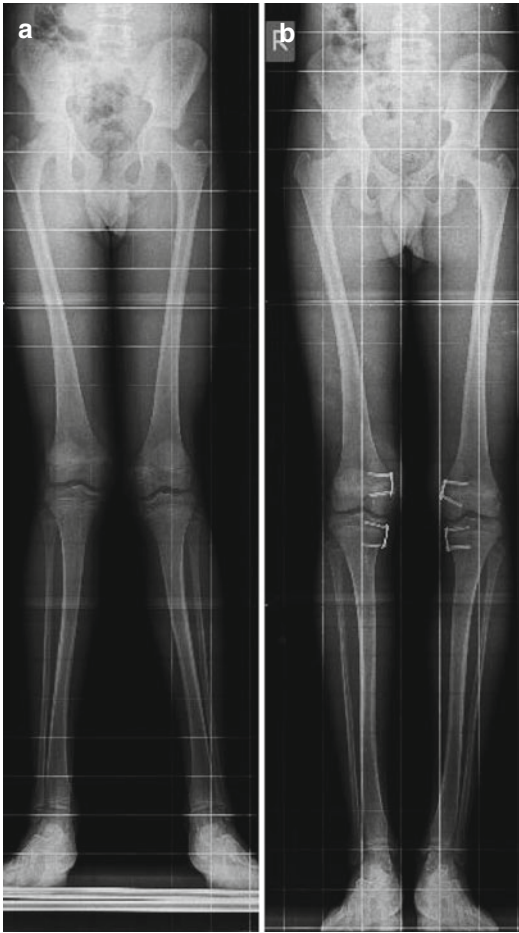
A 13-year-old male patient with bilateral genu valgum deformity. (a) Treatment with medial femoral and tibial hemi-epiphysiodesis. Eighteen-month follow-up radiographs showing normal alignment (b)
